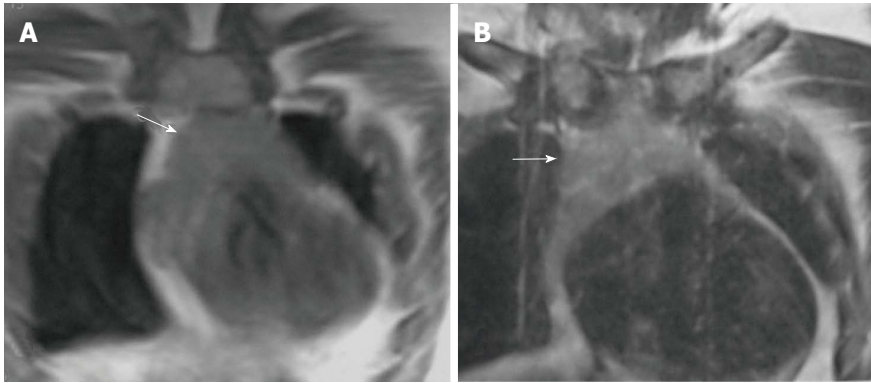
Normal appearance of the thymus on magnetic resonance imaging in a 1-year-old boy. Coronal T1WI (A) and T2WI (B) show that the signal intensity of the thymus gland is homogeneous (arrow in A and B), greater than that of the muscle on T1WI and isointense to that of fat on T2WI.
